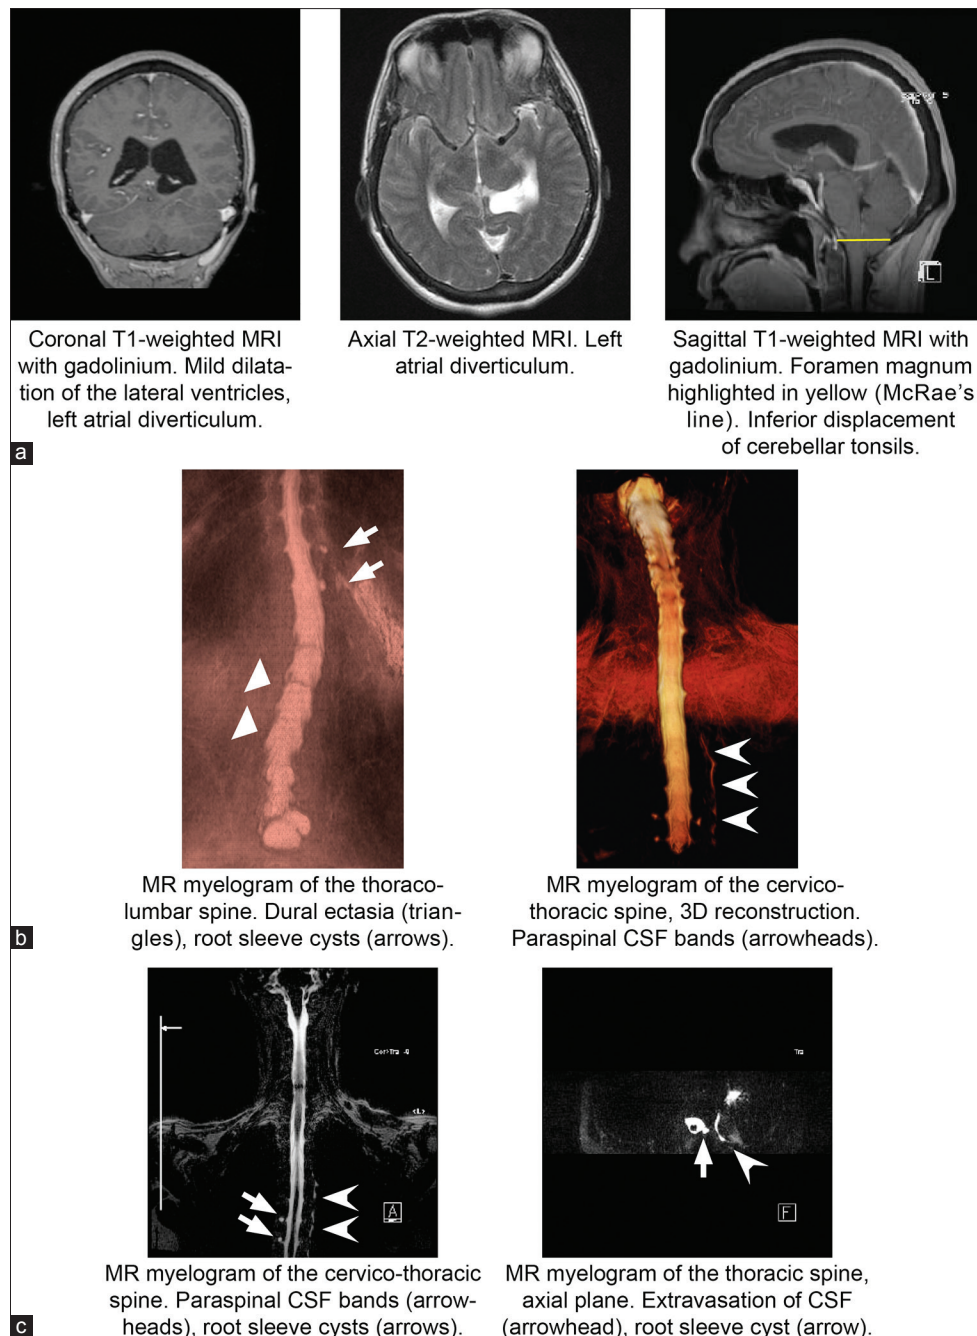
Diagnostic imaging. (a) Coronal and sagittal T1 with gadolinium and axial T2 MRI demonstrating mild dilatation of the lateral ventricles, left atrial diverticulum, and inferior displacement of the cerebellar tonsils (McRae's line in yellow). (b) MR myelography of the thoraco-lumbar and cervico-thoracic spine with 3D reconstruction demonstrating lumbar DE (triangles), root sleeve cysts (arrows), and paraspinal CSF bands (arrowheads). (c) MR myelography of the cervico-thoracic spine demonstrating root sleeve cysts (arrows) and extravasation of CSF with paraspinal CSF band (arrowheads)
